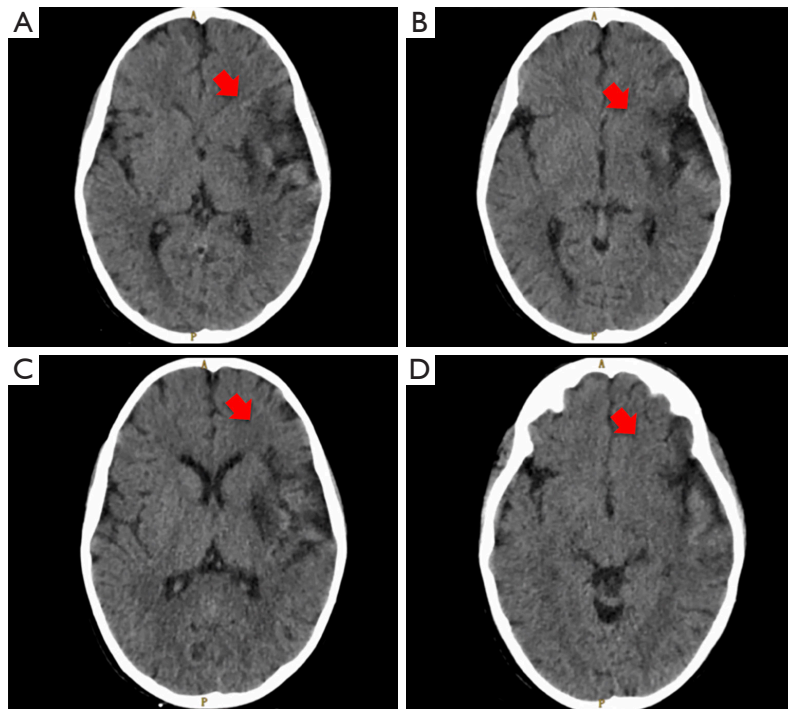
Contrast-enhanced brain computed tomography (transverse sections A, B, C, and D). Arrows show ischemic infarction affecting the internal capsule knee, lenticular nucleus, external capsule, insula lobe, and temporal lobe.
